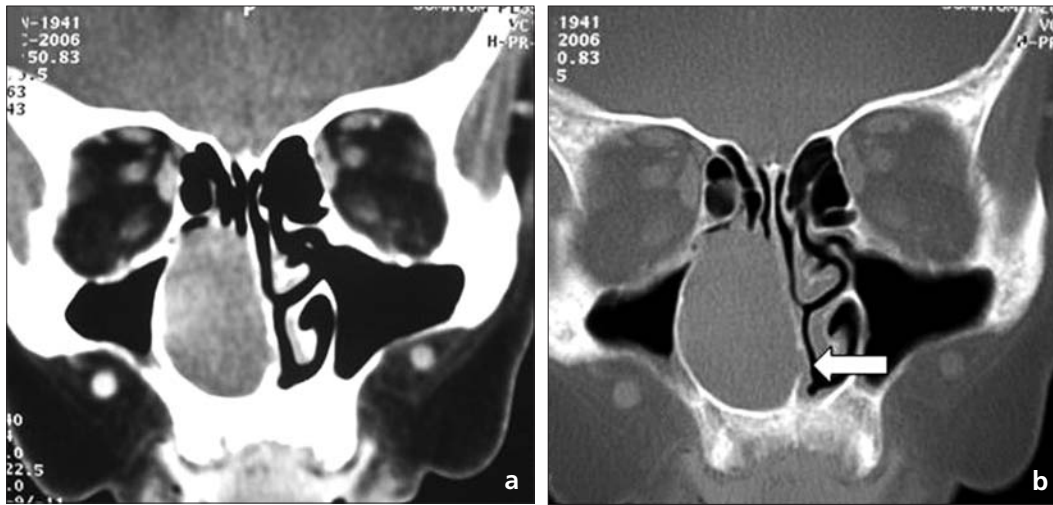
a, b. Contrast-enhanced coronal CT images with soft tissue (a) and bone (b) window settings. A well-defined, heterogeneously enhancing mass occupying the right nasal cavity can be seen. Note the remodelling of the nasal septum (arrow, b).
